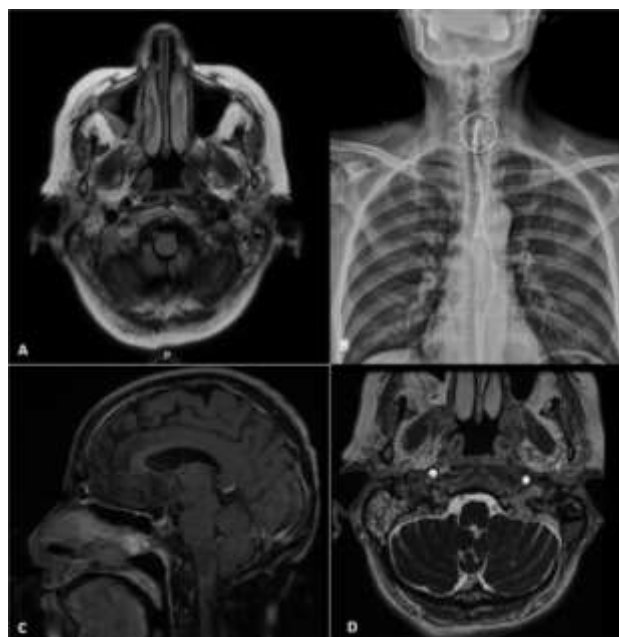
(A) Axial Brain MRI on the skull base with no evidence of neoplasm, bone lesion or jugular foramen occupation; (B) A modified barium swallow study, with silent aspiration; (C) Sagittal Brain MRI without evidence of lesion at brain stem, especially at midbrain level; (D) Axial Brain MRI with evidence of ethmoidal sinusitis.
